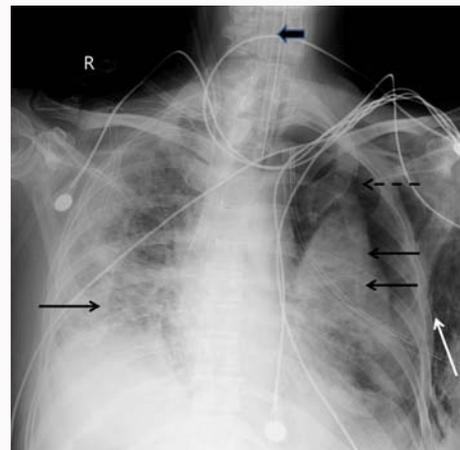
AP chest radiograph of 66-year-old male showing diffuse consolidation bilateral lung fields (black arrow). Note the left pneumothorax devoid of bronchovascular markings (dashed arrow), overlying the collapsed – consolidated left lung (double arrows). There is evidence of subcutaneous emphysema seen as air lucencies in the soft tissue (white arrow). Also note the endotracheal tube *in situ* (block arrow).
